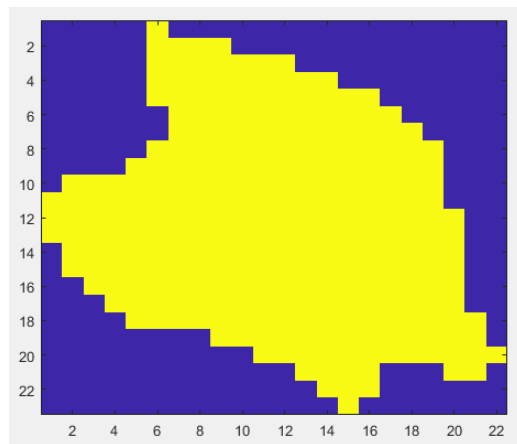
Final 2D tumor numerical model from MRI 05.
